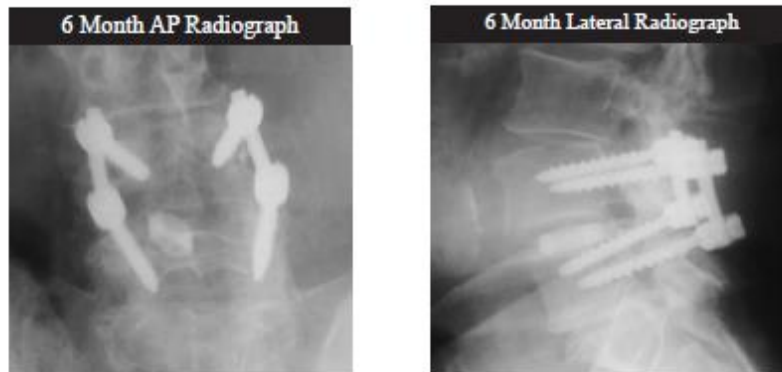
Radiograph imaging of SI
